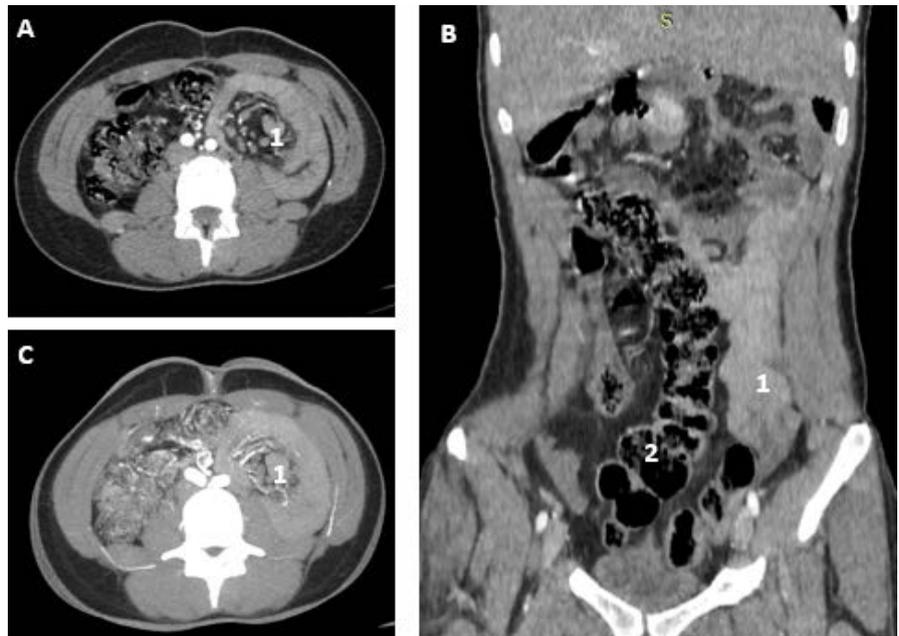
Abdominal-pelvic CT scan, late arterial time (45 s), axial slice (A), coronal reformation (B), MIP axial slice (C). (A) and (C) Whirl sign (1) suggestive of small bowel volvulus. (C) Small intestine (1) attached to the abdominal wall and pushing the sigmoid colon (2) medially.
